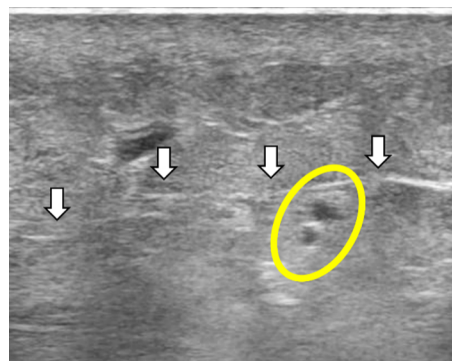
B-mode image of lymphatic ultrasonography. Of the D-CUPS (Doppler, Cross, Uncollapsible, Parallel, Superficial fascia) indices, P, and S are explained. A yellow circle indicates lymph vessels and white arrows indicate the superficial fascia. Two lymphatic vessels run parallel to each other just below the superficial fascia.
